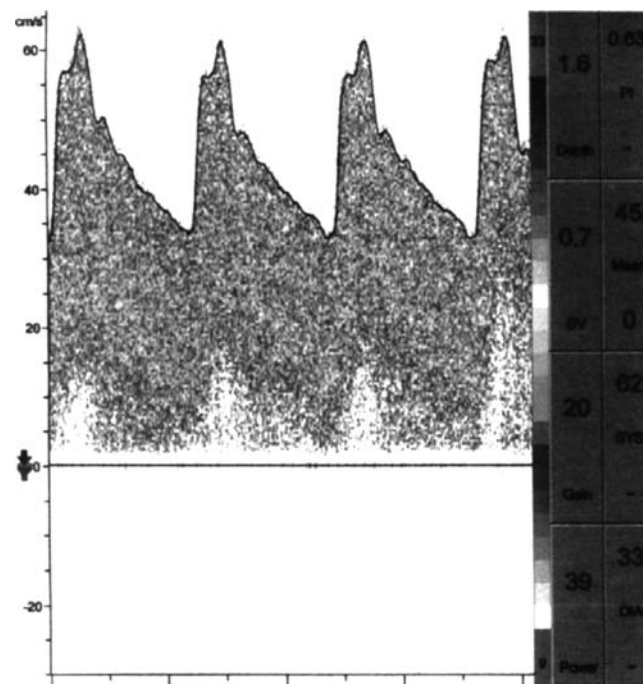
The middle cerebral artery flow velocity obtained by intraoperative microvascular Doppler after surgical manipulation for clip placement. The mean flow velocity has increased to 45 cm/sec.
